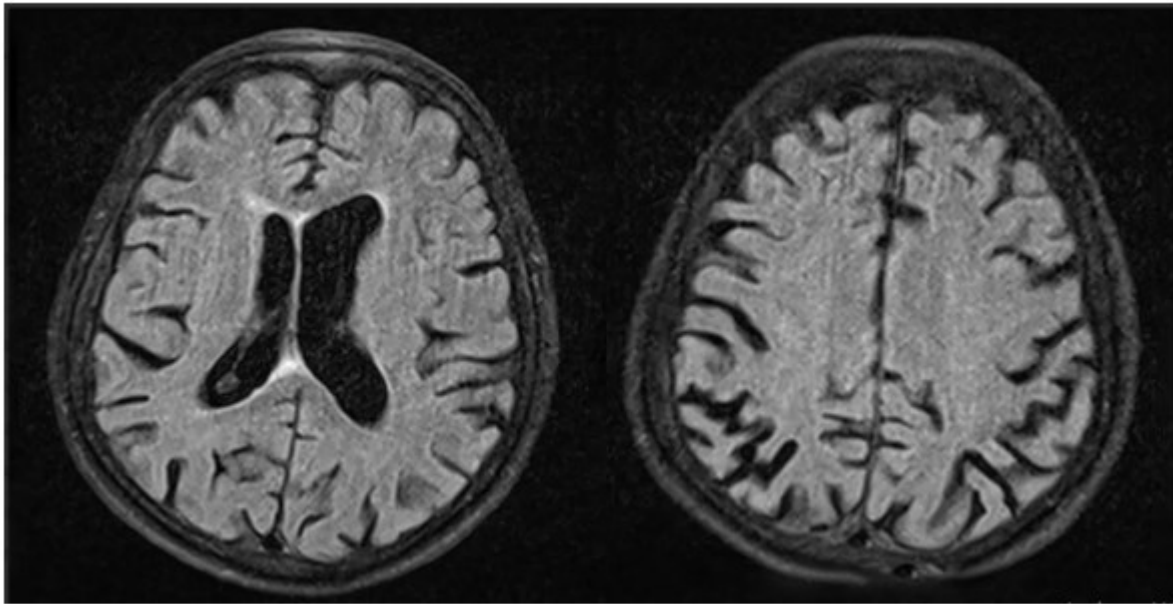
T1 weighted MRI of the patient showing cortical atrophy
